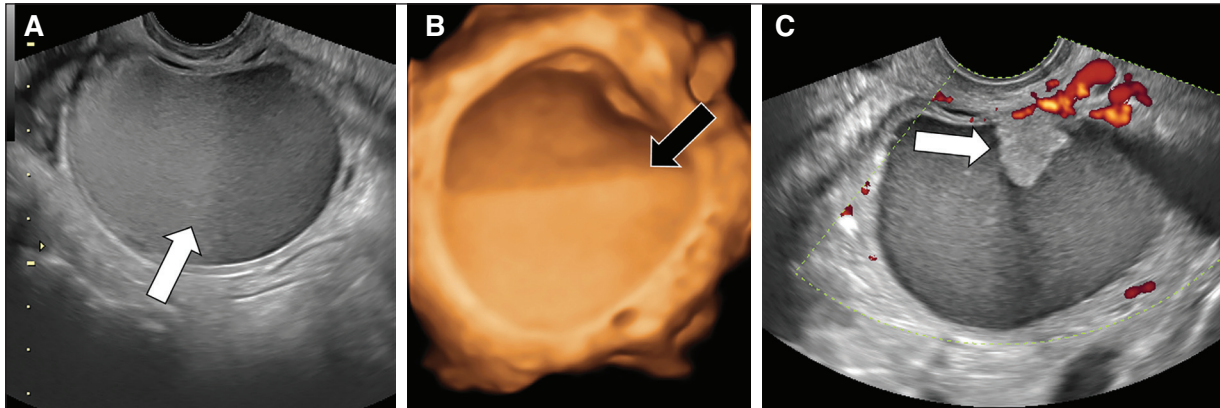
Ovarian endometrioma in a 25-year-old woman with dysmenorrhea A: TVU image shows an endometrioma with thick content, ground glass echogenicity and fluid-fluid level (arrow). B: three-dimensional image from TVU better demonstrating the fluid-fluid level within the cyst (arrow). C: TVU with power Doppler US image demonstrating a hyperechoic peripheral nodule (arrow) without internal flow. TVU: transvaginal ultrasound; US: ultrasound.
